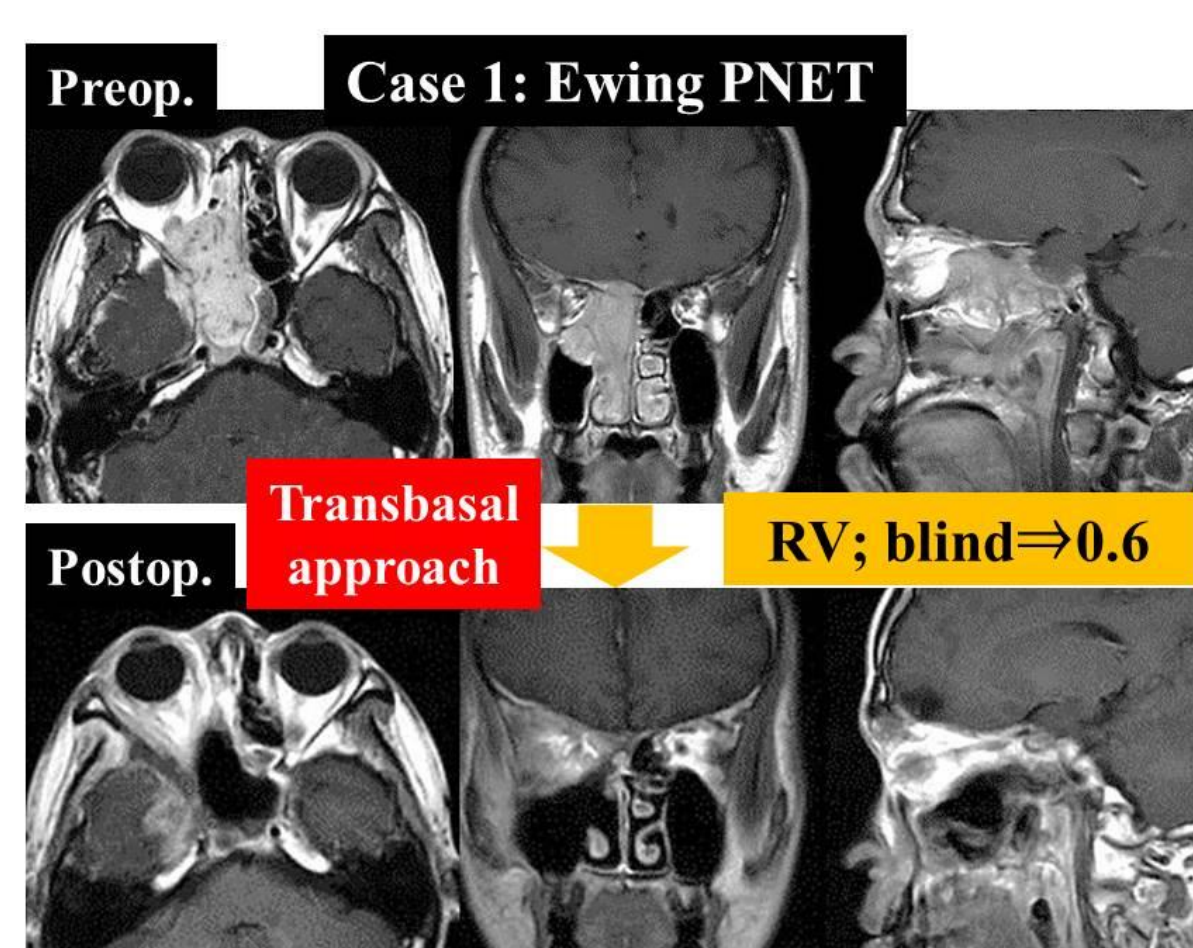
Pre- and postoperative MRI on Case 1
